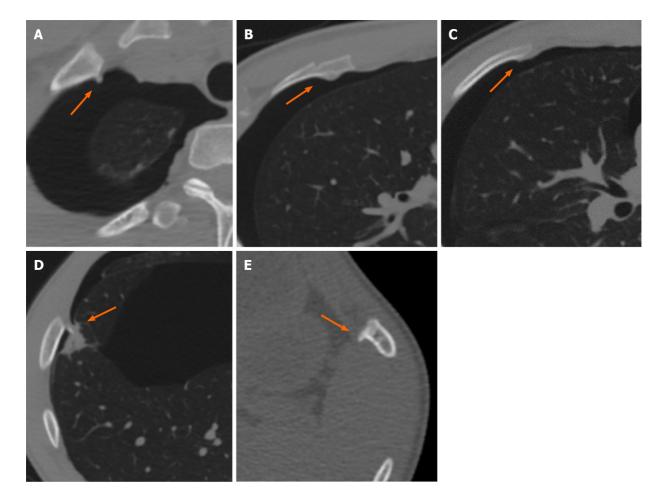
Computed tomography scan shows exostoses of five ribs. The right first and seventh ribs were sharp and protruded into the thoracic cavity. A: Rt. (right) first rib; B: Rt. third rib; C: Rt. fourth rib; D: Rt. seventh; E: Left ninth rib. Rt.: Right.
